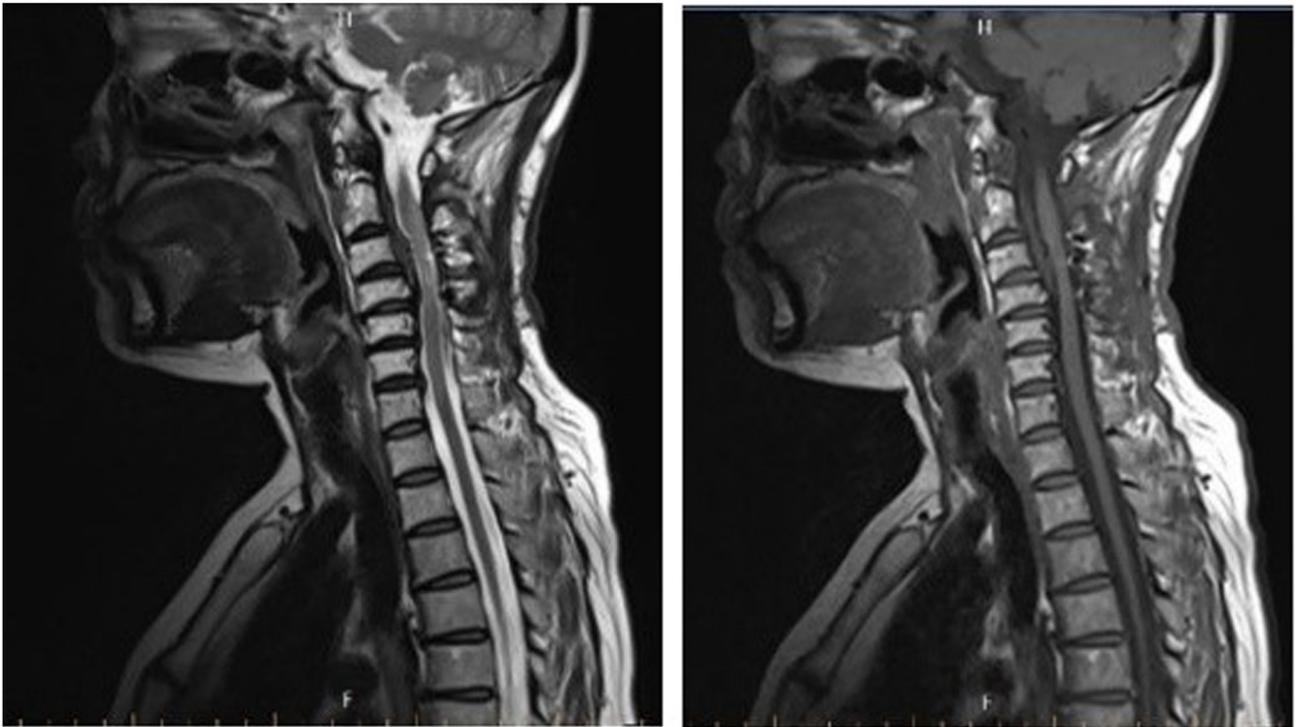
Cervical spine magnetic resonance imaging in October 2023.
